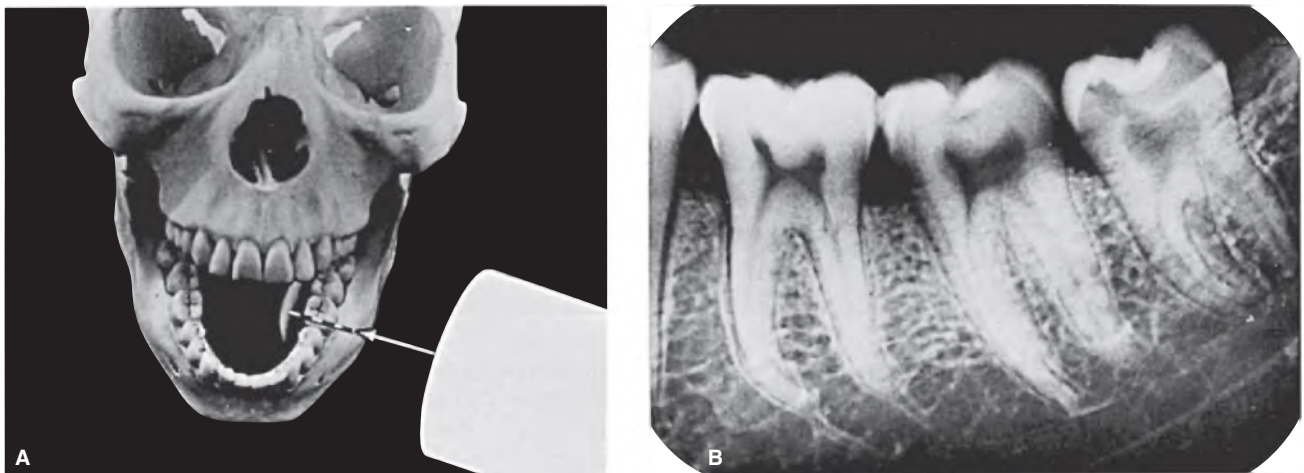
10 Mandibular molars. A. Central ray directed at right angle to film positioned parallel to arch. B. Limited information is gleaned from the radiograph because of superimposition of structures and canals. (Reproduced with permission from Walton RE.²⁷)
